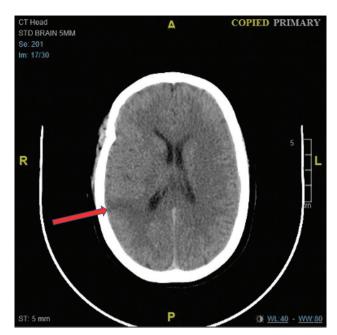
Case 1 computed tomography showing low-density change in right middle cerebral artery territory.
